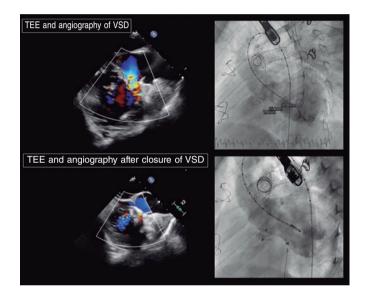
Ventricular septal defect (VSD) in a patch in a patient with tetralogy of Fallot. The upper images reveal the presence of the defect both on the transesophageal echocardiography (TEE), and the angiography. The lower images—also from TEE and angiography—reveal the defect being closed after KONAR-MF device implantation (Lifetech, China).
